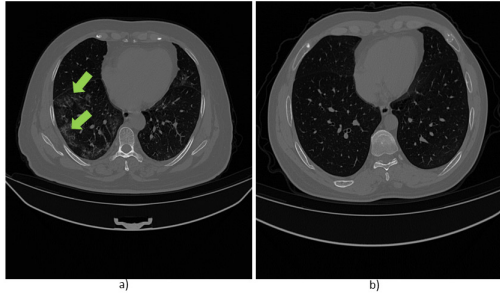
Images obtained from a CT scan of a patient of the database. a) Slice with lesion (GGO indicated with green arrows), b) slice without lesion.
